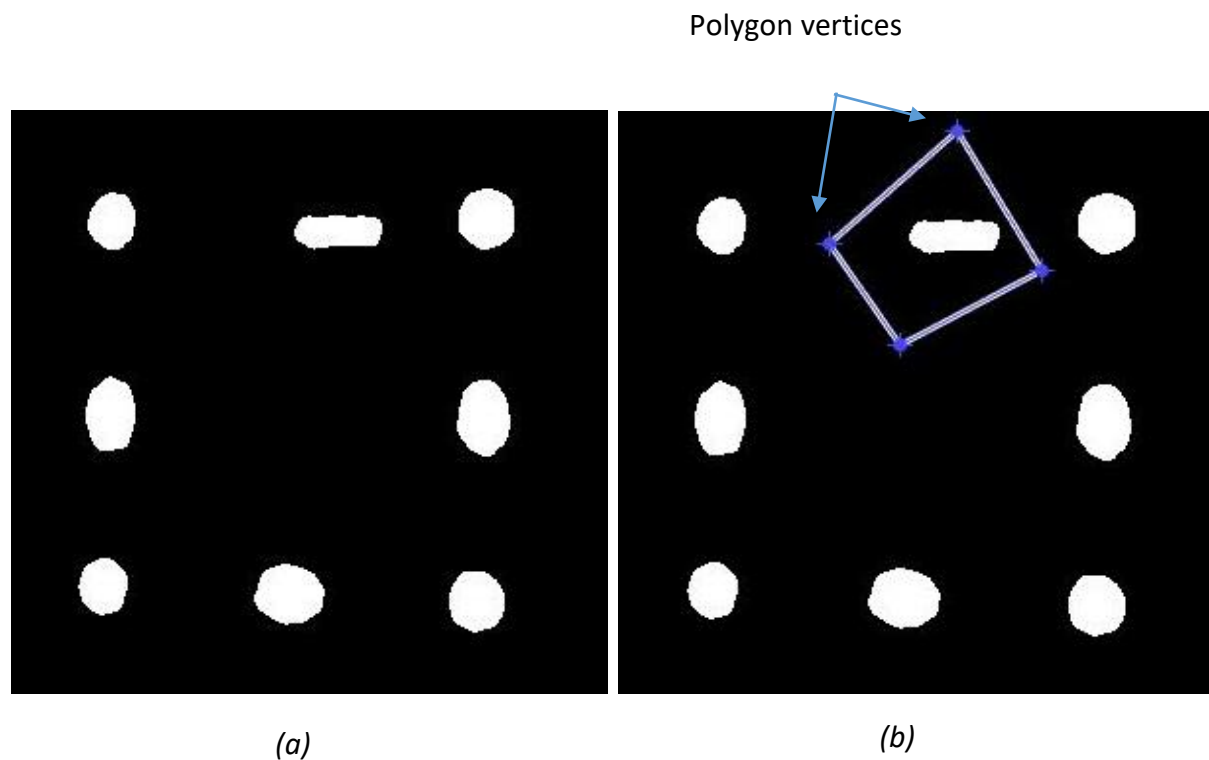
The binarized image of the captured-MR image after denoising by the Gaussian filter and contrast enhancement.*
